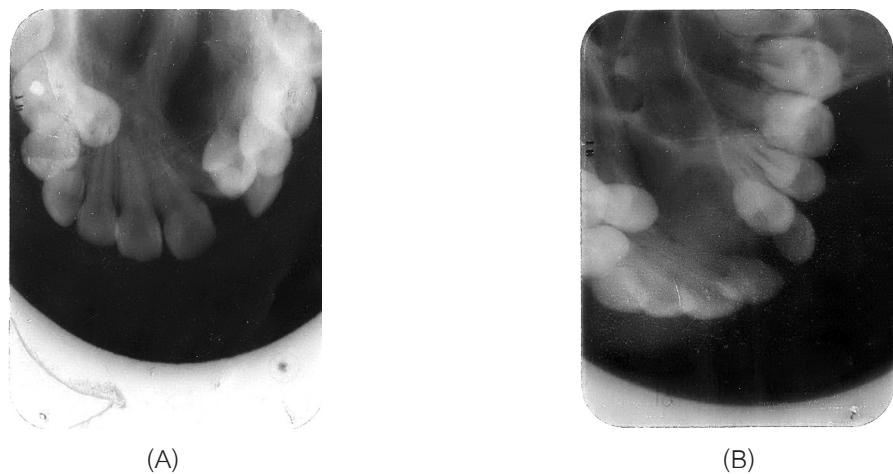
Occlusal radiograph (A) Before bone grafting (B) After bone grafting
